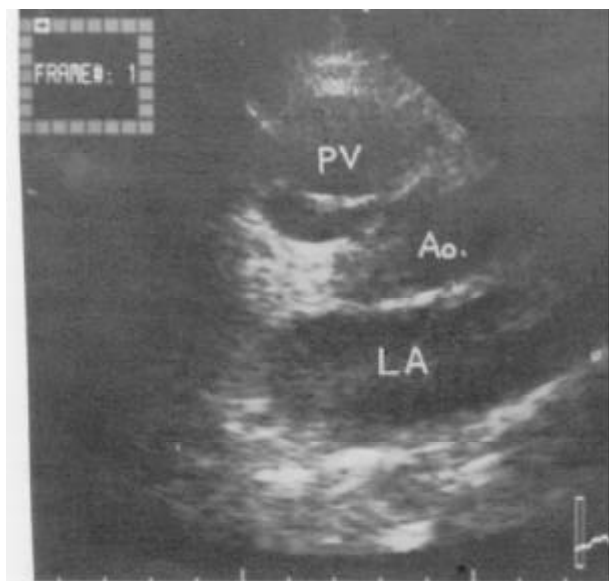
Parasternal image on second left intercostal space for evaluating the pulmonary valve at the level of implantation. Two leaflets can be identified, a large left anterior one and a smaller right posterior one as well as two commissures. PV | Pulmonary valve; Ao | Aorta; LA | Left atrium.
